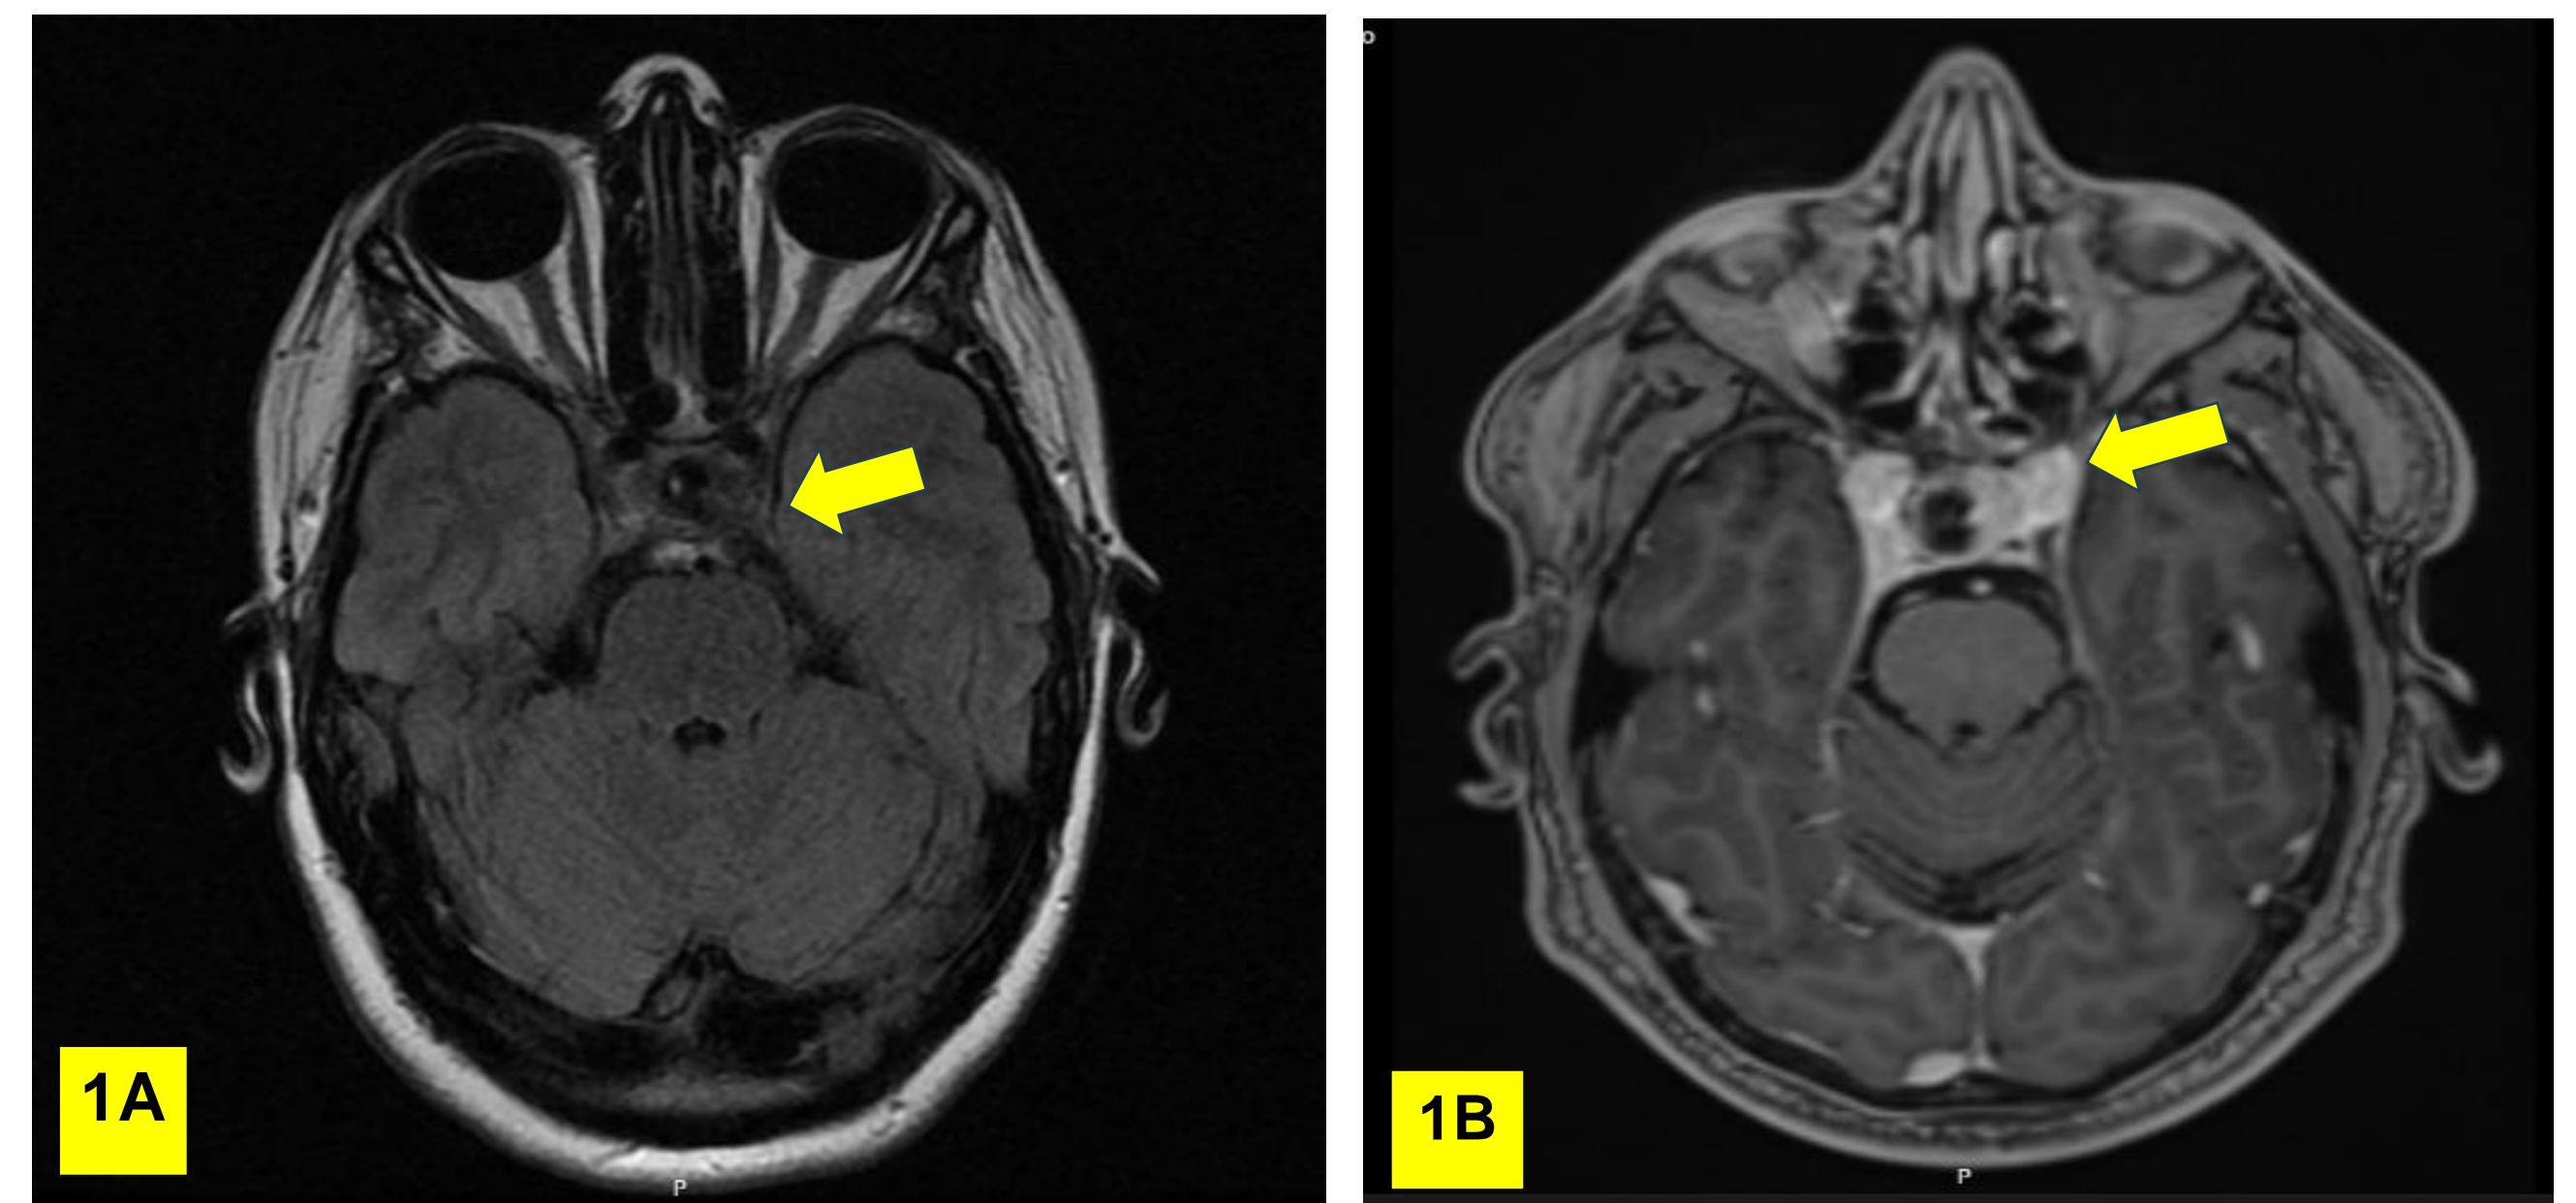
In Case 1 (1A), the cranial brain MRI with axial plane demonstrated the location of the lesion (yellow arrow). In case 2 (1B) the CT showed a residual lesion after two surgeries observed (yellow arrow).
